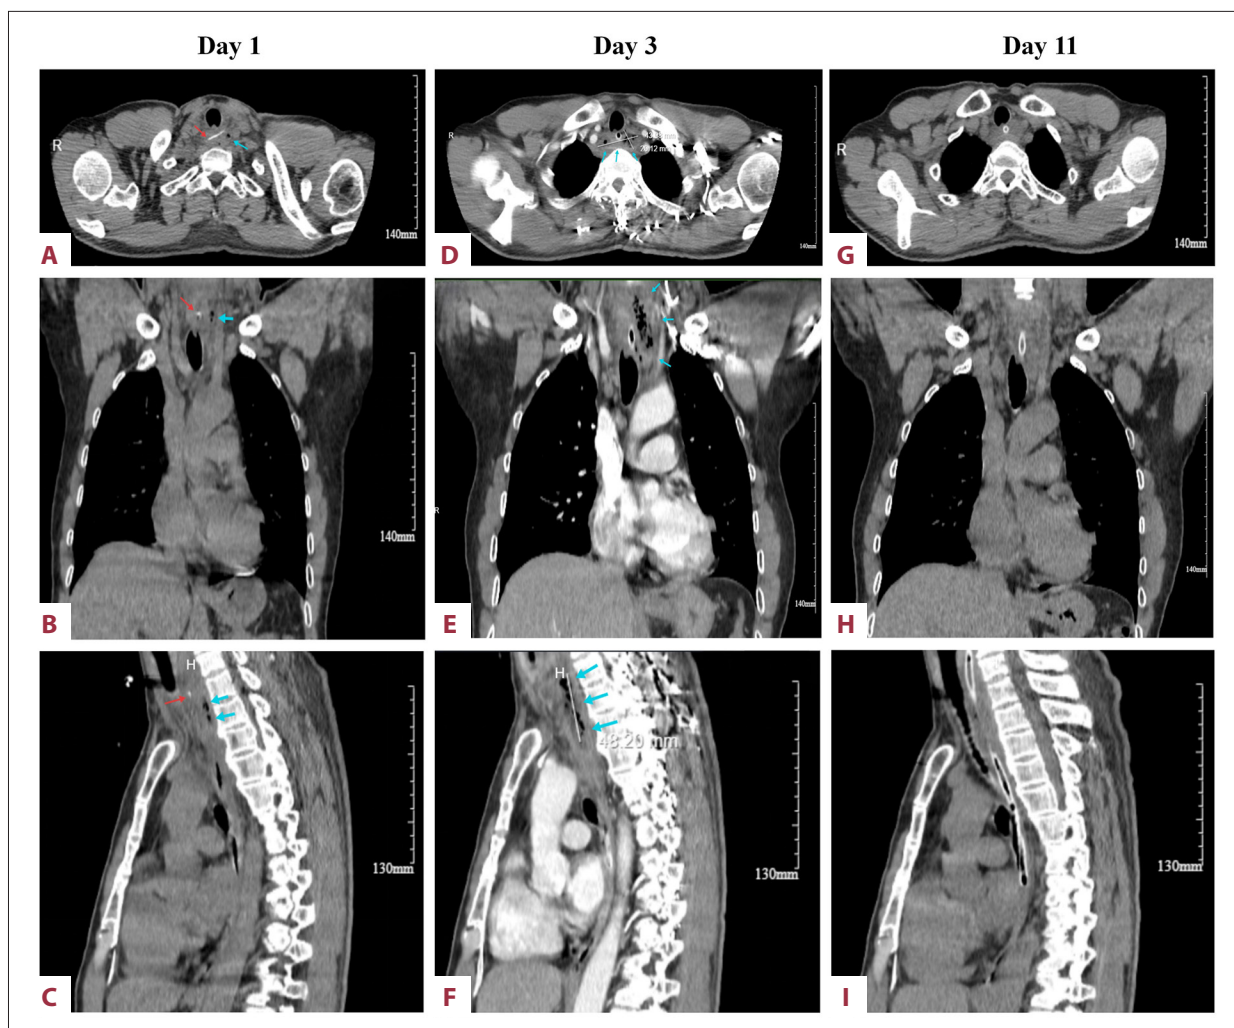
Serial computed tomography (CT) images demonstrating the evolution of cervical esophageal perforation with abscess formation. (A-C) Pre-admission CT images showing the fish bone (red arrows) impacted in the cervical esophagus with periesophageal air (blue arrows). (D-F) CT images on day 3 of hospitalization (48 hours after admission) showing abscess expansion. (D) Axial view demonstrating the abscess measuring 43 × 20 mm at its maximal cross-section. (F) Sagittal view showing a craniocaudal length of approximately 48 mm; the blue arrows indicate the abscess cavity. (G-I) CT images on day 11 of hospitalization (8 days after initiation of simplified negative-pressure nasoesophageal drainage) showing resolution of the abscess with residual esophageal wall edema.
